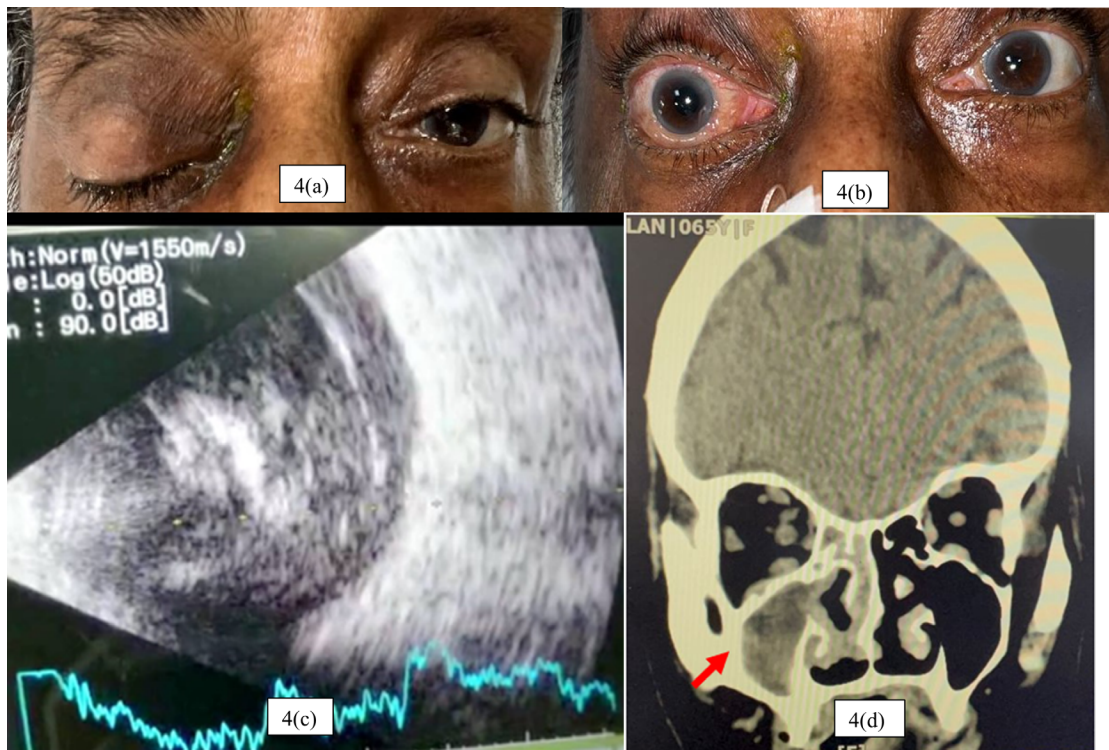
(a): Right Eye Ptosis with Lid Swelling. Figure 4 (b): Right Eye Conjunctival Injected with Chemosis. Figure 4 (C): B Scan Ultrasonography Showing Vitreous Loculations and scleritis. Figure 4 (d): Magnetic Resonance Imaging (MRI) Brain Coronal View Shows Extensive Pansinusitis and Erosion of the Inferior Orbital Wall.
